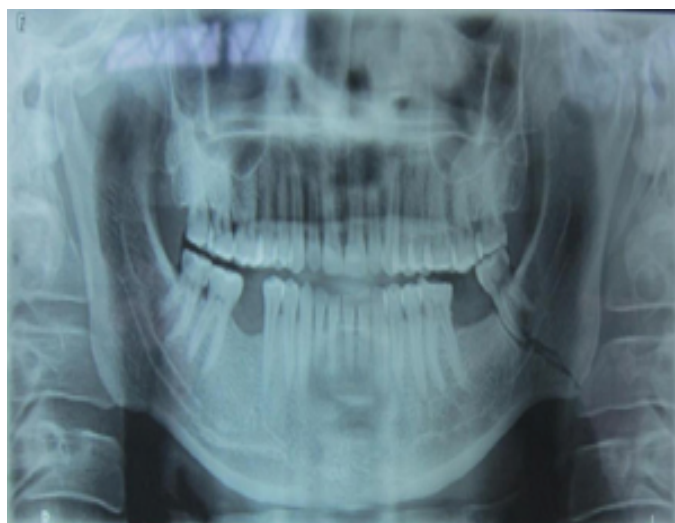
Orthopantomogram showing fracture mandible
